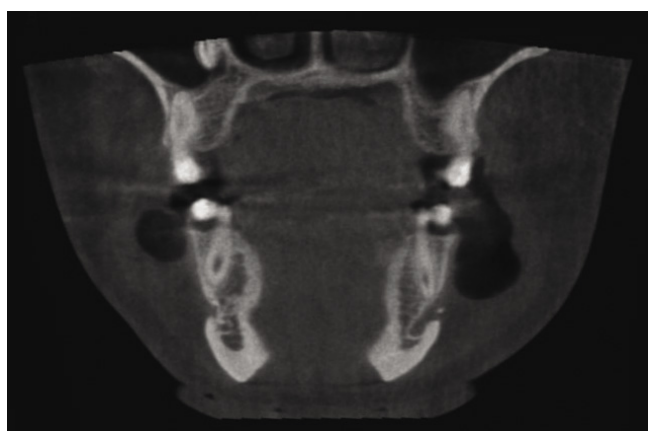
Frontal CBCT slice of the mandible with a barely visible exophytic lesion at the mandibular border
